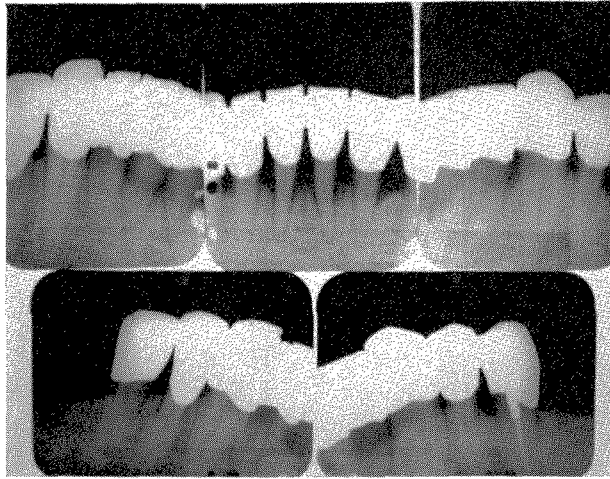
These roentgenograms were taken when the splint was inserted in 1951.
